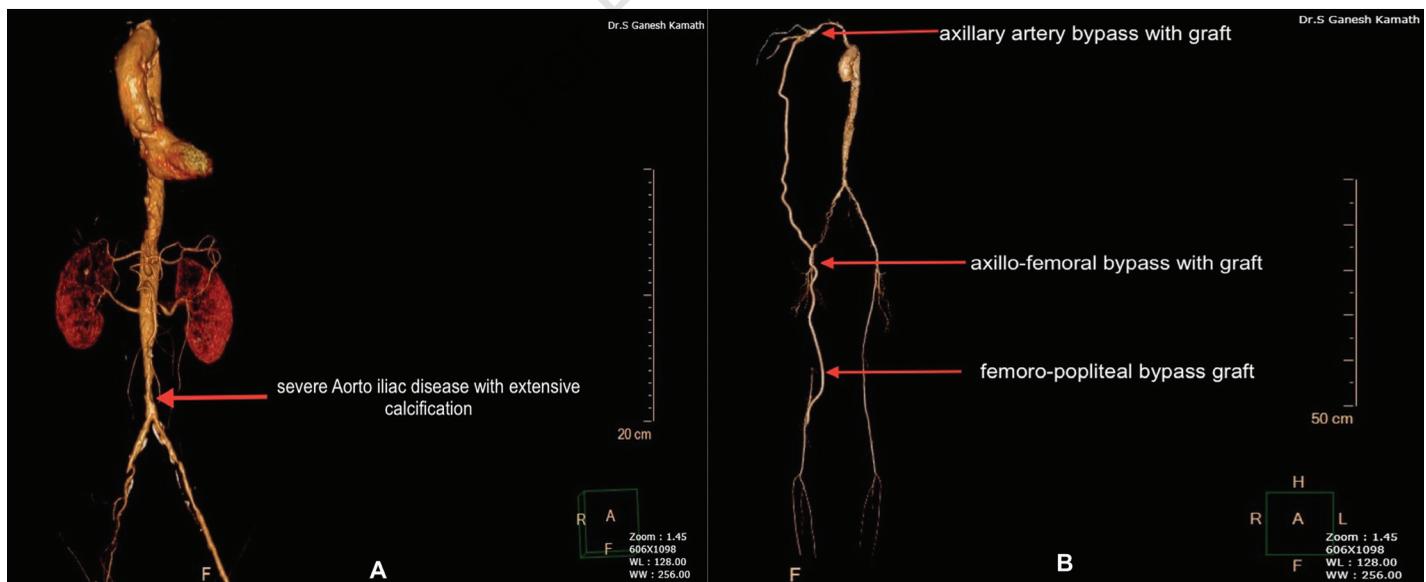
Reconstructed 3D image of computed tomographic angiography (CTA). (A) Extensive aortoiliac disease. (B) Postoperative check CTA showing graft flow from right axillary artery to popliteal artery after right axillopopliteal bypass with PTFE graft.
